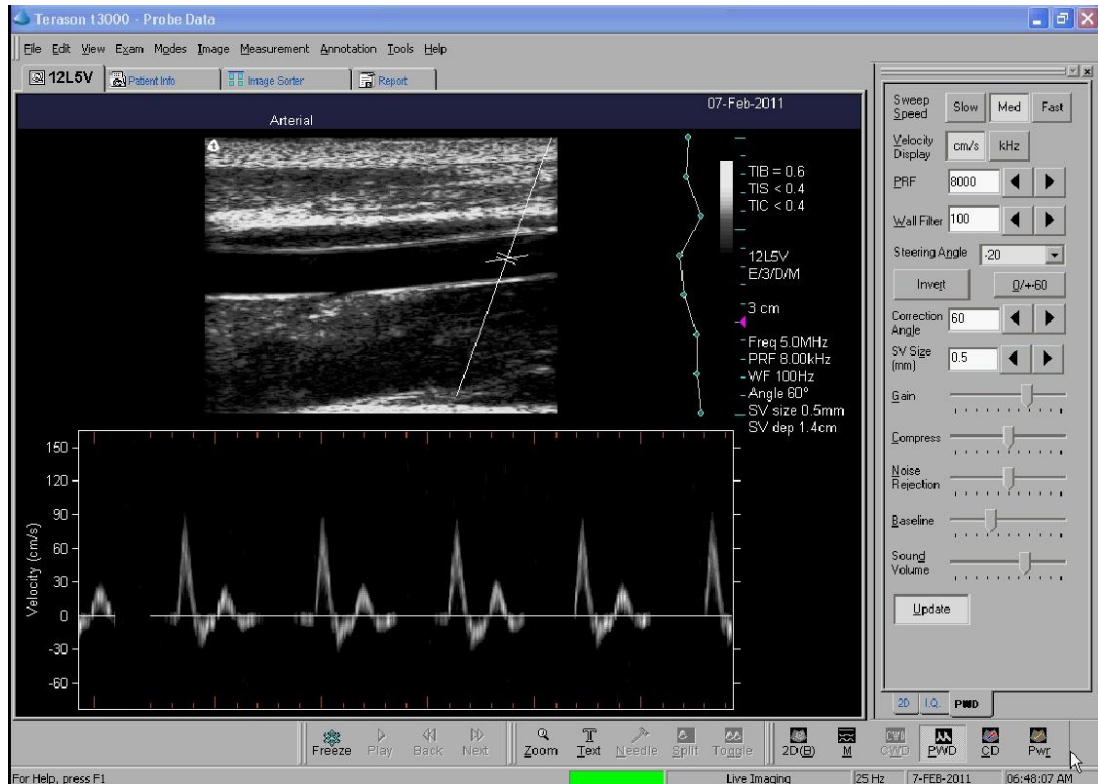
Ultrasound interface. The top half of the screen represents the B-mode 2-dimensional image of the brachial artery. Below, is the Doppler trace of the blood flow velocity moving through the brachial artery.
